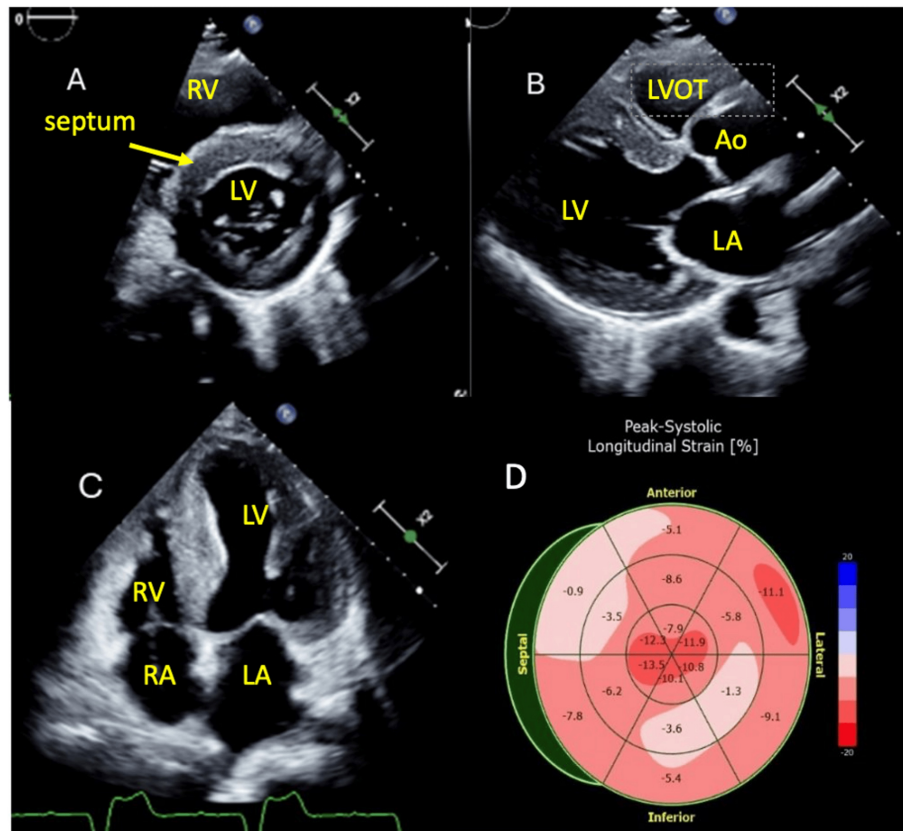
Transthoracic echocardiography showing (A) parasternal short axis, (B) parasternal long axis, and (C) apical four-chamber views all showing increased left ventricular thickness. (D) Global longitudinal strain with apical sparing
